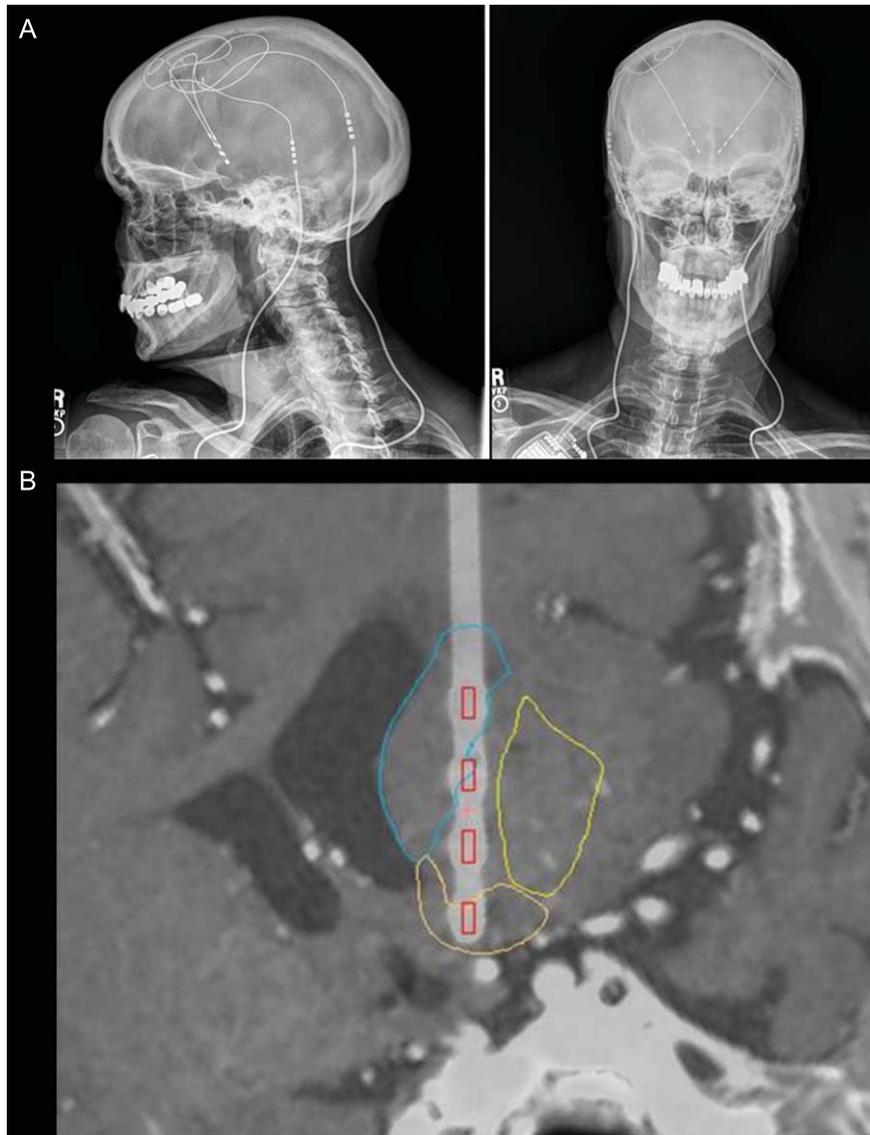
(A) Lateral and anterior-posterior postoperative skull X-ray. Images demonstrate location of implanted Medtronic DBS lead model #3391 in the ventral striatum/ventral capsule bilaterally. (B) Postoperative CT with MRI Fusion. Image demonstrates location of implanted unilateral left Medtronic DBS lead model #3391 in the ventral striatum/ventral capsule. The CT has been reformatted to along the axis of the DBS lead. Each contact is three mm in length, spaced four mm apart. Structures of relevance: ventral striatum (nucleus accumbens—orange) and surrounding structure of ventral capsule (putamen—yellow and caudate—blue). The CranialVault atlas and the CRAVE software suite were used for anatomical segmentations, image registration, as well as for electrode localization and visualization. The rectangular box represents the contacts for the DBS electrodes.
